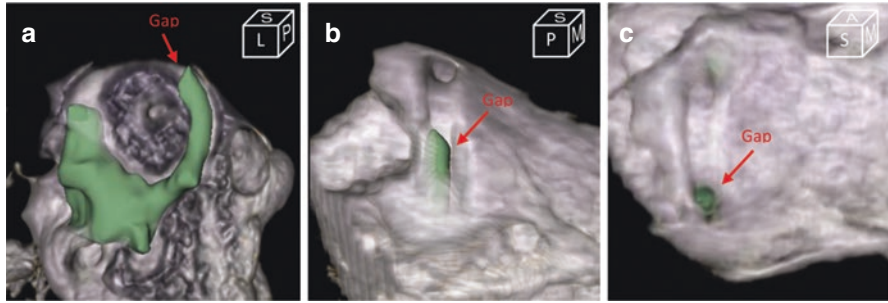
Novel 3D reconstruction technique using fused CT-MRI in the postoperative setting after plugging, showing residual dehiscence. (Reprinted with permission from [66].) 33-year-old man with left ear SCD following SSC plugging via MCF. A residual defect is noted in the posterior limb on combined 3D reconstruction of CT and MRI imaging. T2-weighted MRI signal represents the fluid in the SSC with the surrounding bony CT. (a) parallel view of SSC (Poschl view). (b) posterior–superior view of SSC. (c) Superior view of SSC. A indicates anterior; CT, computed tomography; L, lateral; M, medial
